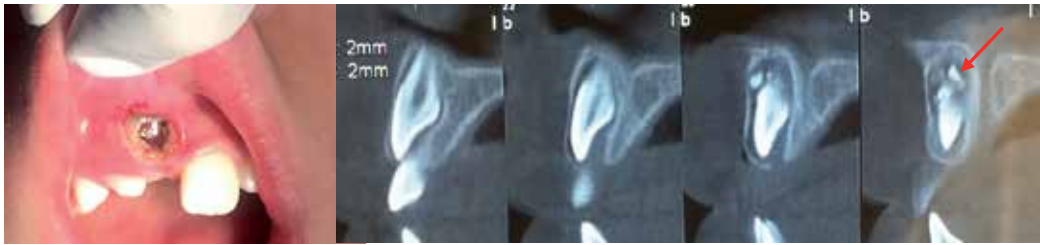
An inappropriate way to expose the impacted left central incisor. Incorrect technique is independent of tools i.e. laser beam or scalpel; a required width of attached gingiva (necessary for periodontal health) has been removed to create a buttonhole window (Left) as an unaccepted procedure with a bonded attachment. On the first right slice of CBCT, an odontoma-like malformation is obvious but has been neglected during the surgical intervention (red arrow).
